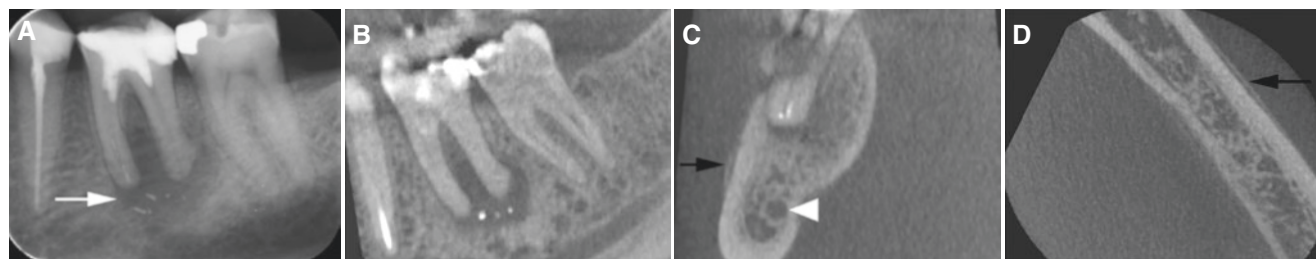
Osteomyelitis with periosteal reaction, mandible; 40-year-old male with variable pain/swelling for about 1 month and pus evacuated from the first molar. (A) Intraoral view shows ill-defined periapical radiolucency (*arrow*) with endodontic material. (B) Oblique sagittal
